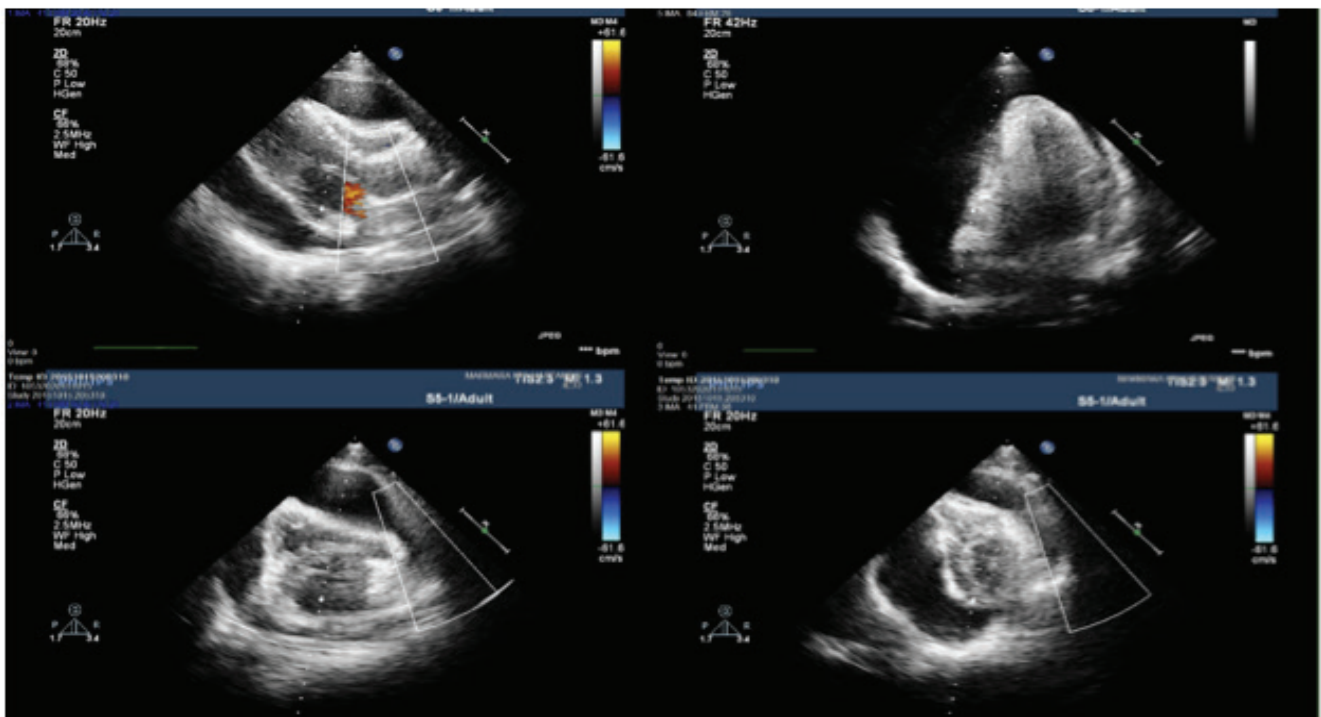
Echocardiographic images before procedure shows right ventricular collapse during diastole
